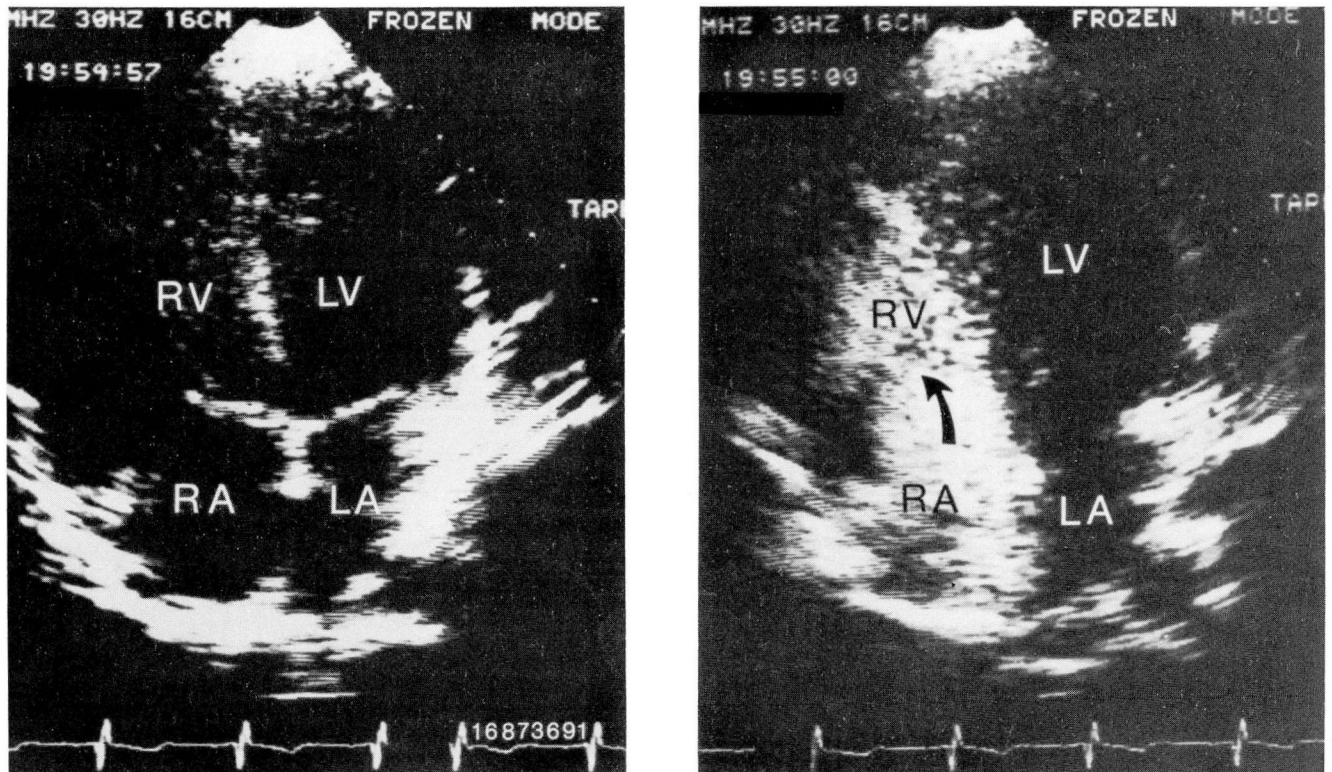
A. Apical four-chamber view in a patient who appeared to have a ventricular septal defect before arrival of contrast agent. B. As the contrast agent arrives in the right side of the heart (arrow), the ventricular septum is proved to be intact. LA = left atrium, LV = left ventricle, RA = right atrium, and RV = right ventricle.
